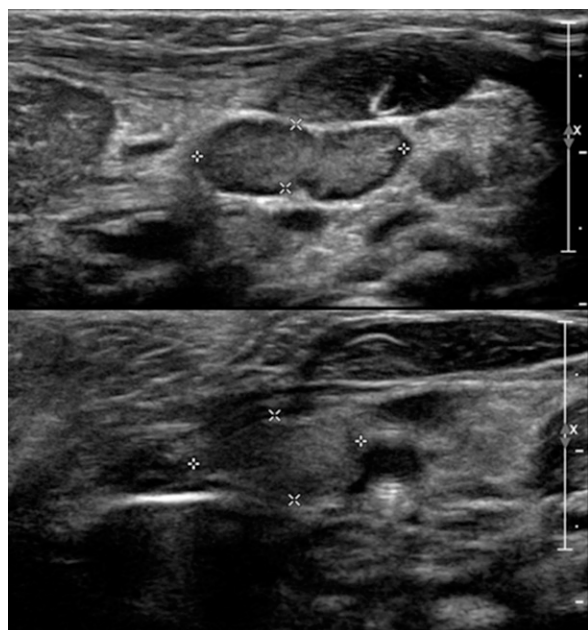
Ultrasonographic scan demonstrating prominent cervical lymph nodes.
